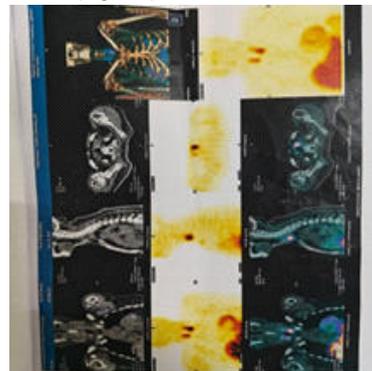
Sestamibi Parathyroid scintigraphy with SPECT-CT
